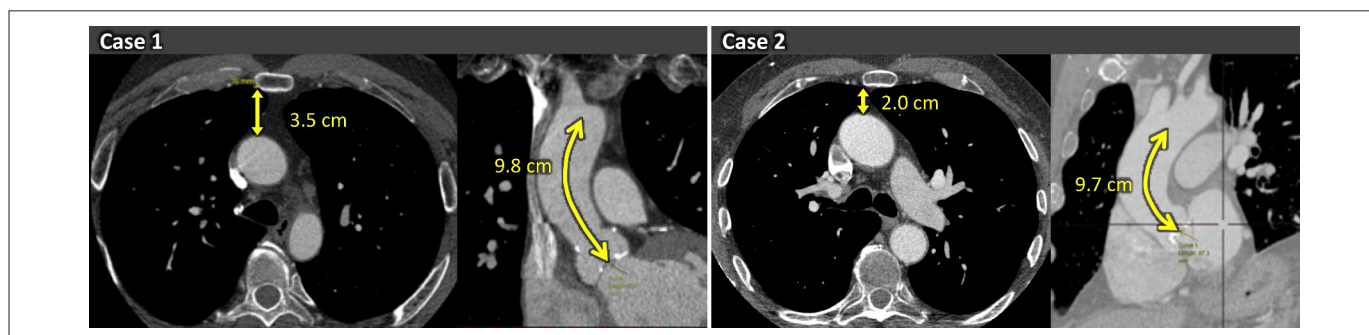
Preoperative computed tomographic scan with contrast media. The length from sternum to ascending aorta (3.5 cm in Case 1 and 2.0 cm in Case 2) was measured at second or third intercostal space. The length between aortic valve and distal end of ascending aorta was used as a length of ascending aorta.
